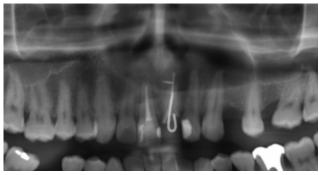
Close up of panoramic radiography where extensive oval radiolucent lesion and corticalized limit on the anterior maxilla is observed. Central incisors with endodontic treatment and left has a metal pin.
